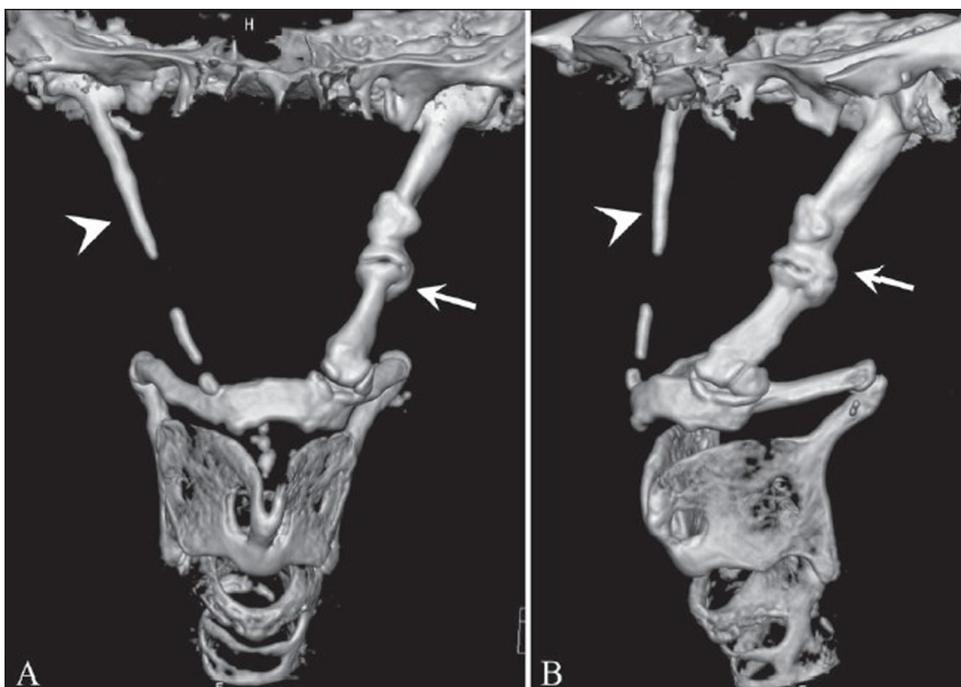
Stylohyoid syndrome: 3D CT reconstruction (from Raina D, Gothi R, Rajan S. Eagle syndrome. *Ind J Radiol Imaging* 2009;19:107–108).
